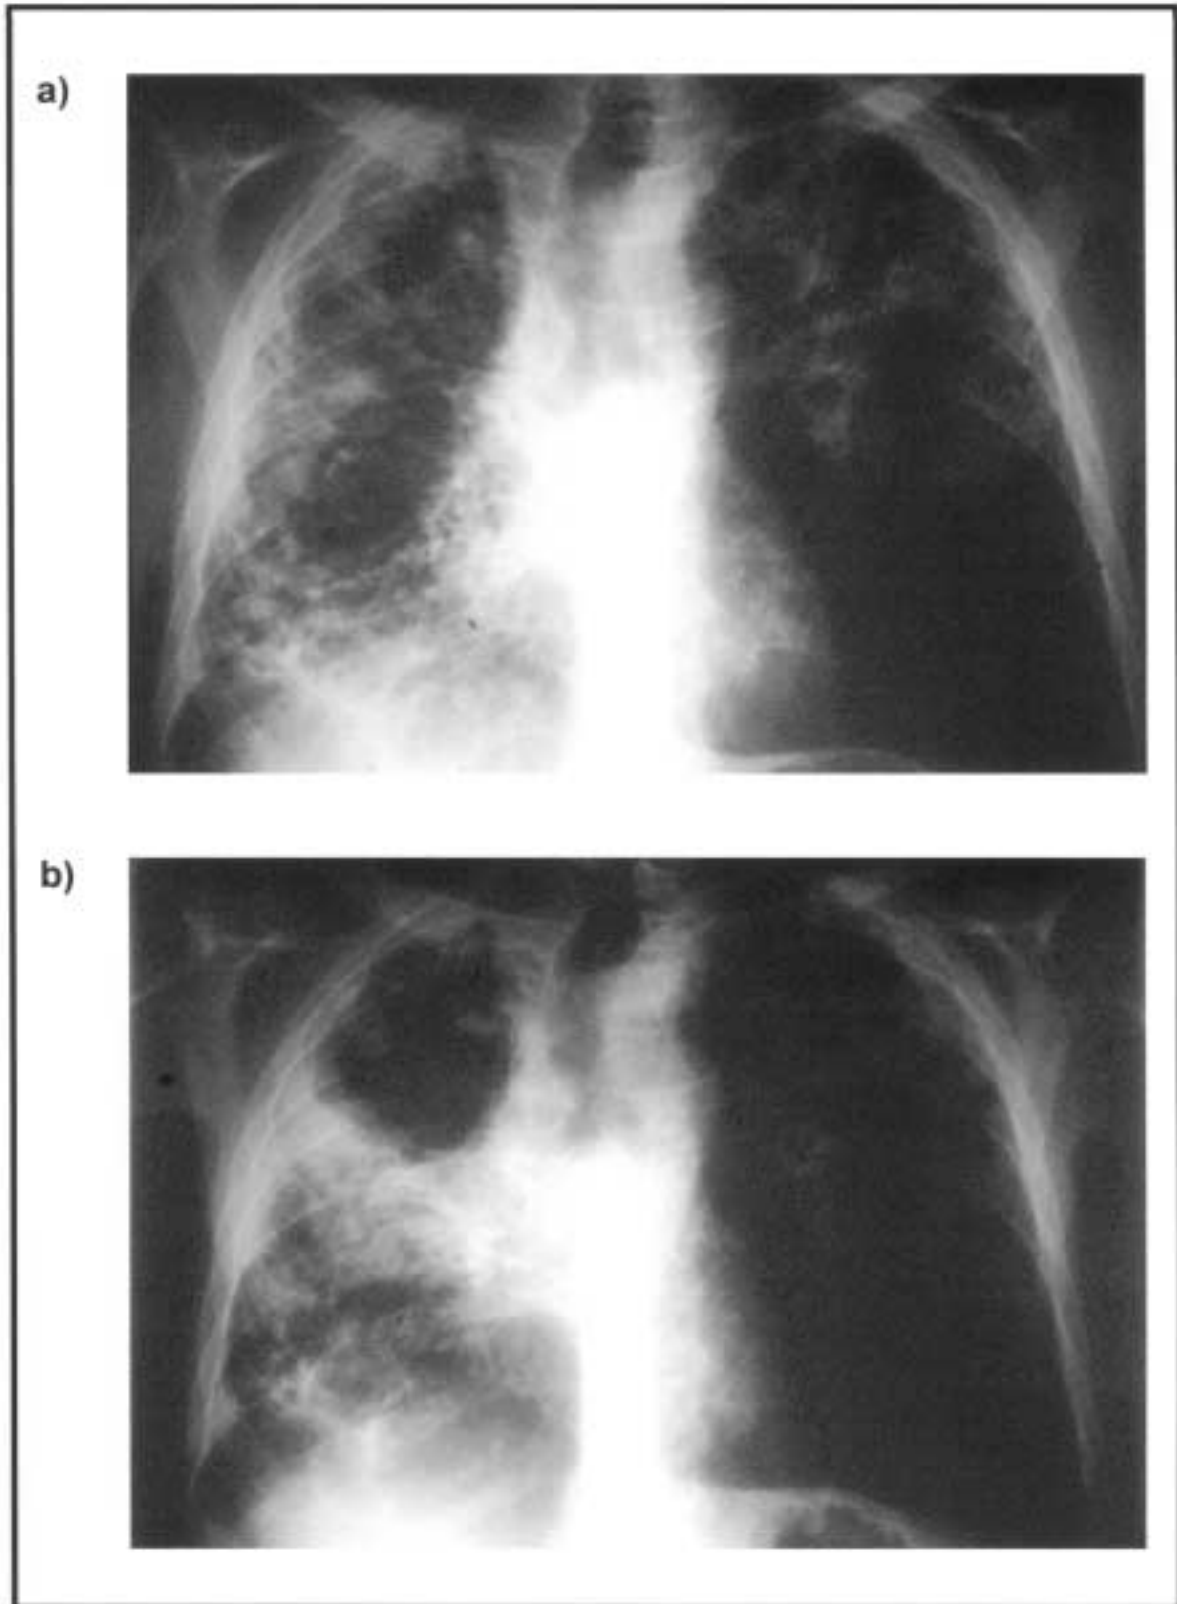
X-rays obtained in February 1998 (a) and April 1999 (b), of the chest of a 58-year-old patient.
